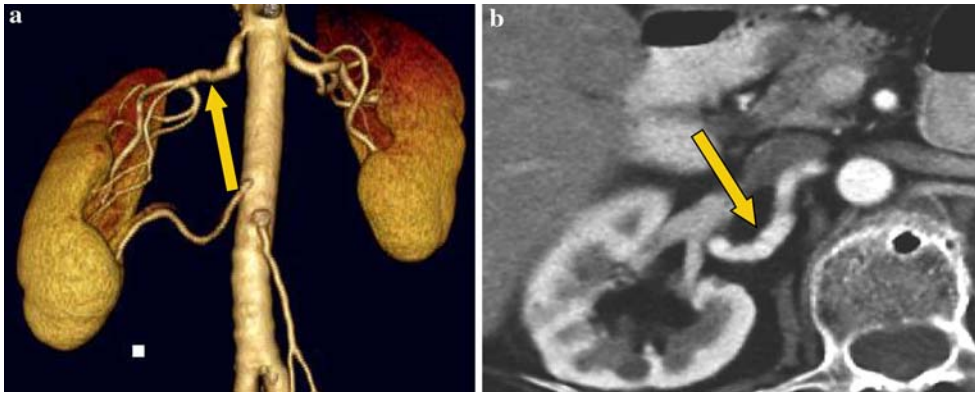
CTA of renal arterial fibromuscular dysplasia. Volume-rendered (A) and axial CT (B) of the renal arteries demonstrate web-like narrowing of the mid-segment of a renal artery consistent with fibromuscular dysplasia.
